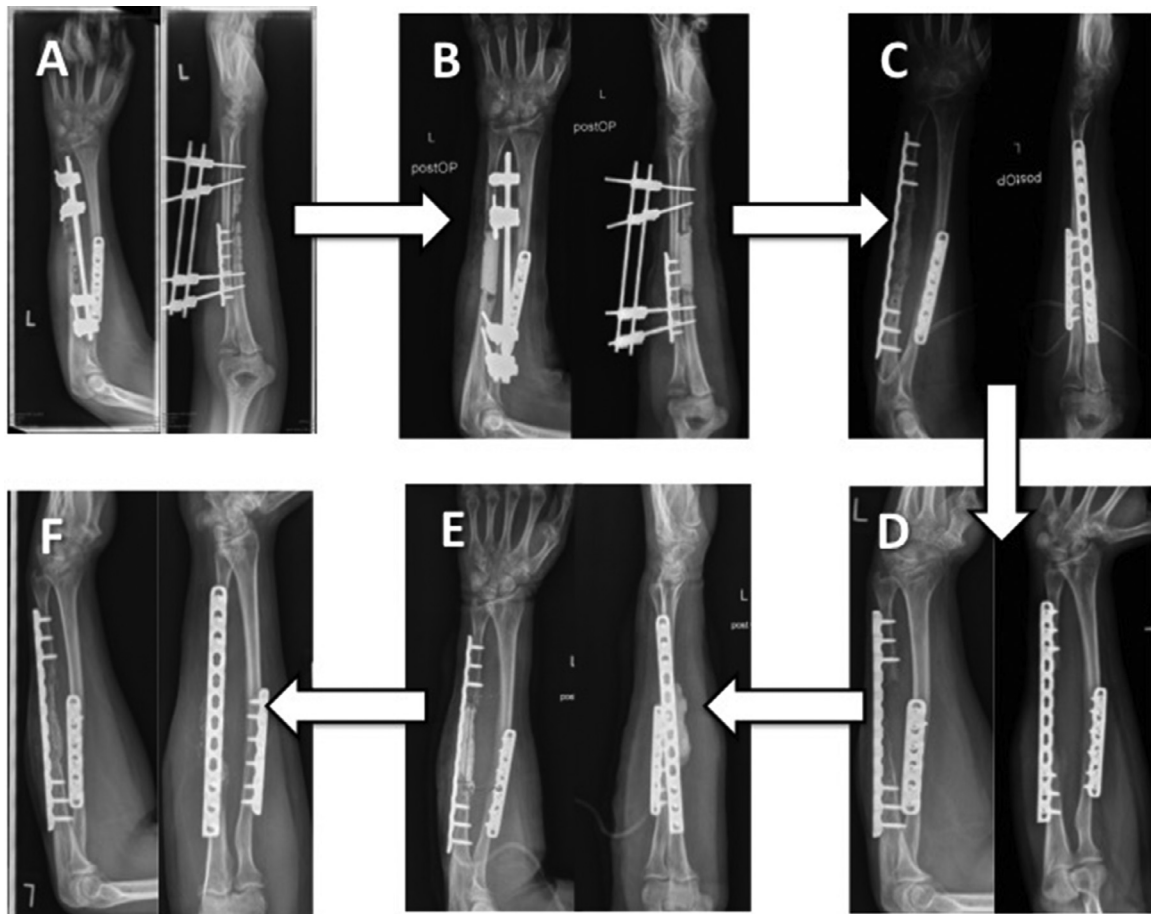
Example of the use of BAG for a second course of induced membrane technique following a failure of the first course in a left ulna midshaft bone defect (A: pre-operative X-Rays, B: First stage X-Rays of the first course, C: Second stage X-Rays of the second course at 3 months, D: Control 1 month later showing the lysis of the graft due to early infection, E: X-Rays at 9 months after the second stage of the second course).
